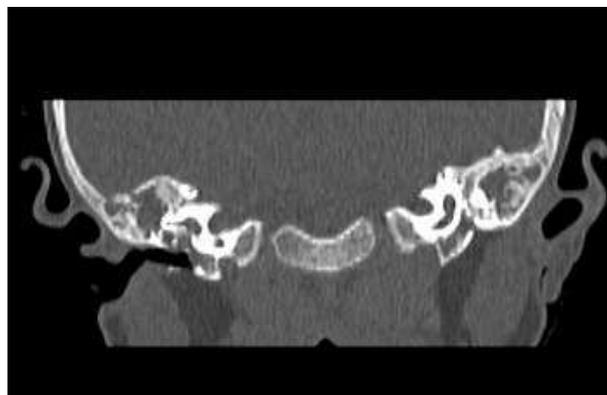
Axial CT scan – Rudimentary ossicles
